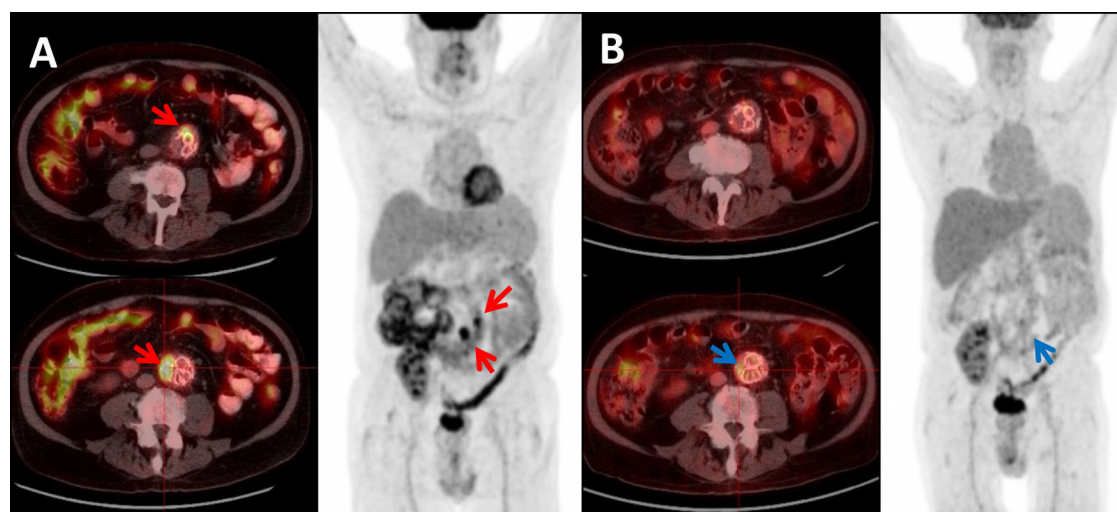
18F-FDG PET/CT showing: (A) Maximum intensity projection (MIP) and Axial-fused PET/CT images: two foci of high intensity FDG uptake in the aortic graft (SUVmax 17.79 and 9.46 respectively), consistent with infection of the graft (red arrows). (B) Same patient and same projections showing: significant decrease in FDG uptake after treatment (SUVmax 3.70 and 2.78 respectively) (blue arrows).
